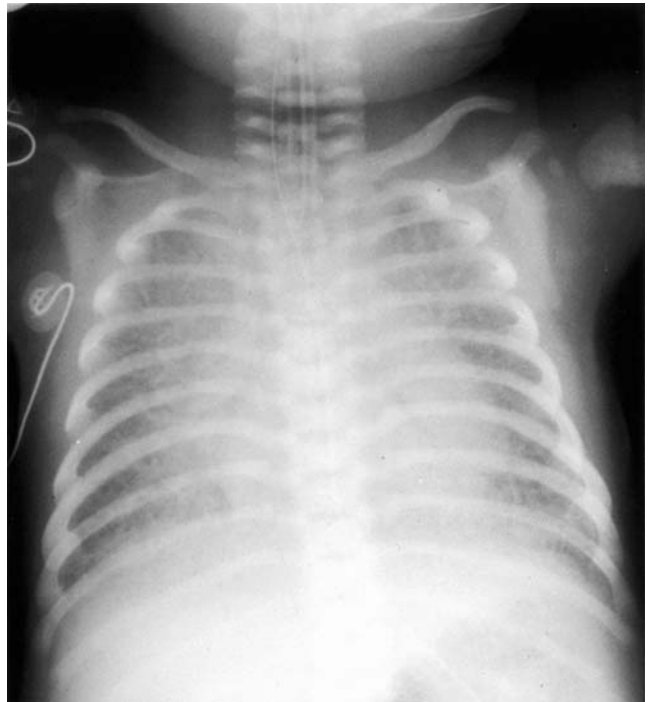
The chest radiograph from a patient with hypoplasia of the left heart and severe obstruction at the atrial septum. Severe pulmonary oedema is obvious.
